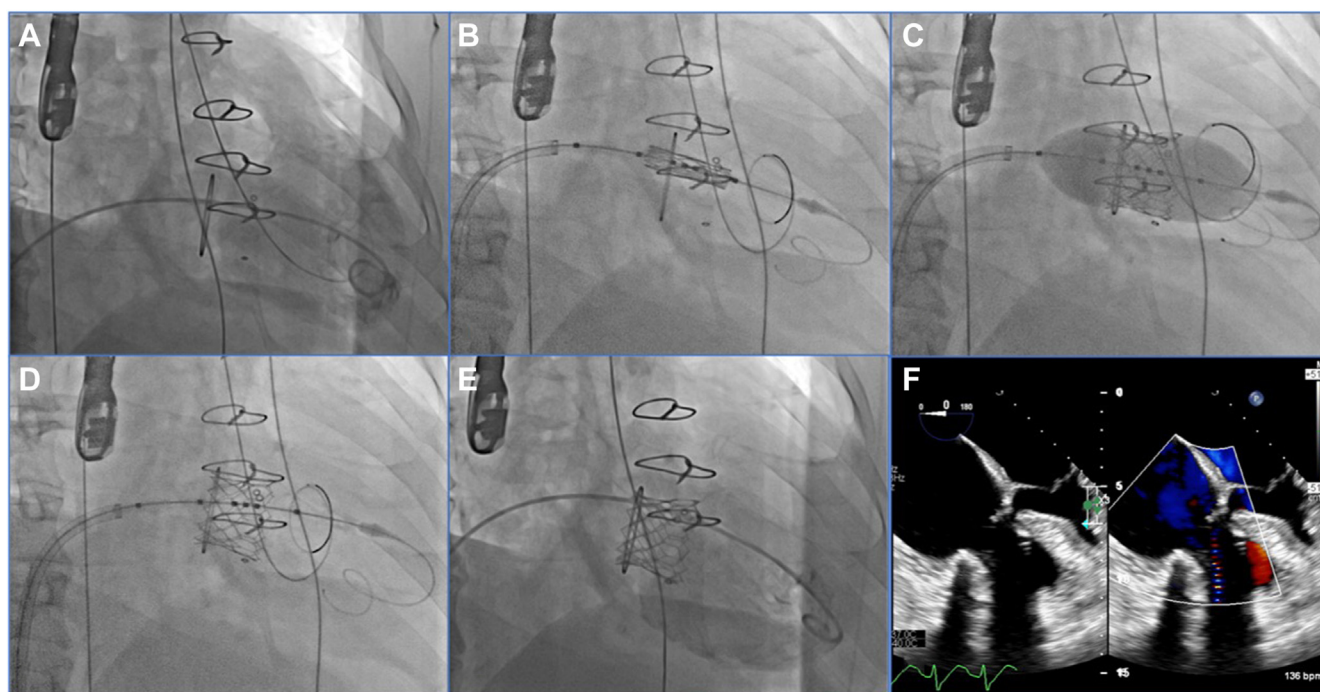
Transesophageal echocardiography and digital subtraction angiography (DSA) images showed that the procedure achieved good results (as shown by data from patient #2). (A) Preprocedural DSA displayed a large amount of blood flow (colored) at the tricuspid valve. (B) The delivery system was positioned in relation to the tricuspid valve. (C) After adjusting the position and the coaxiality, the balloon-expandable valve was inflated. (D) After expansion, the stent was fully unfolded. (E) When the guidewire was withdrawn, DSA showed that the position and shape of the tricuspid valve were ideal and that the stent fit closely to the valve. (F) Postprocedural transesophageal echocardiography showed that the balloon-expandable valve was properly closed, with no paravalvular regurgitation.
